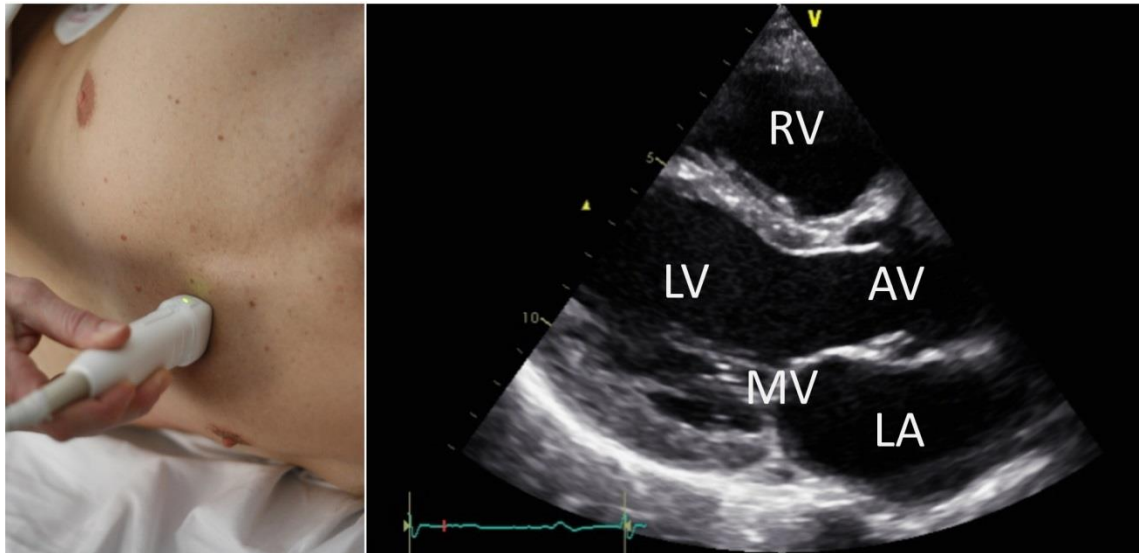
Parasternal long axis. RV: Right ventricle; LV: Left ventricle; AV: Aortic valve; MV: Mitral valve; LA: Left atrium
